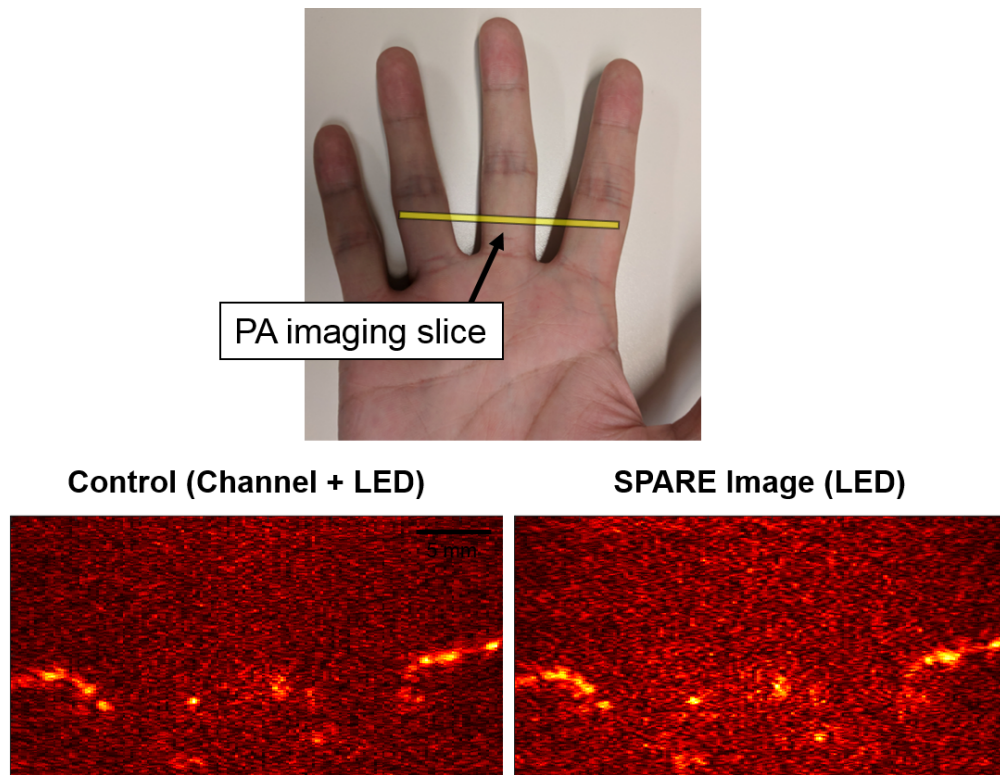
in vivo* PA imaging of human fingers using LED light source. Experimental configuration, ultrasound and PA images of human fingers are shown. PA images were reconstructed using channel data from DAQ device and beamformed RF data with the SPARE algorithm.
